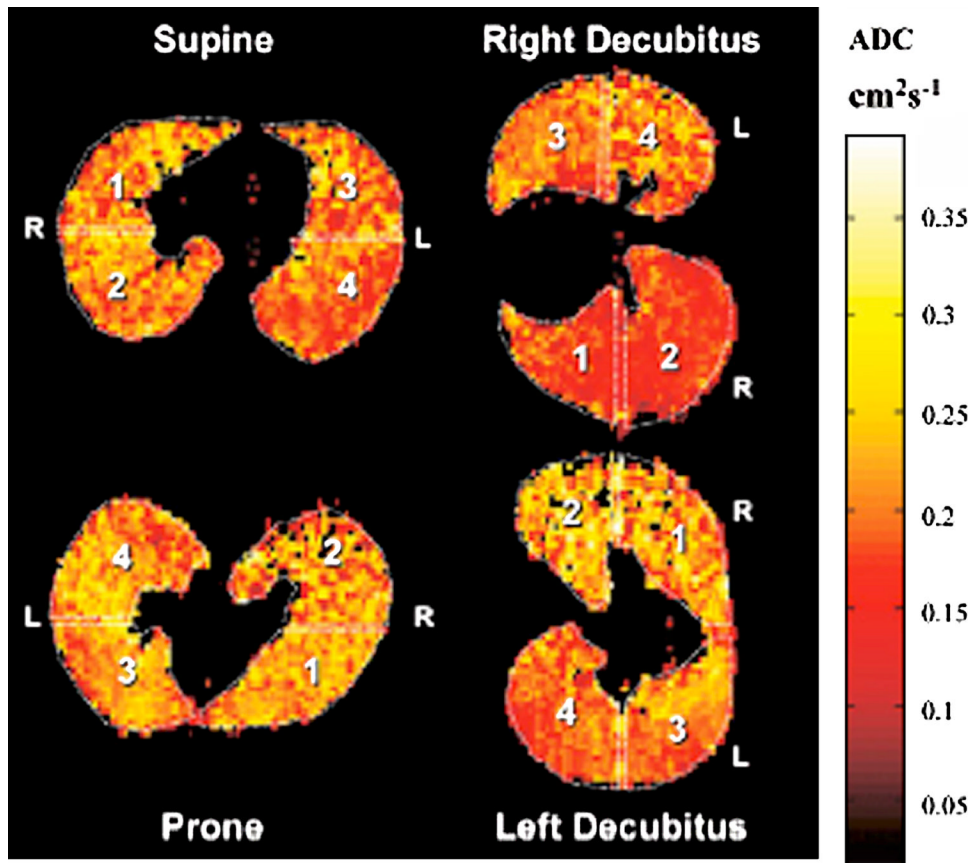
Apparent diffusion coefficient (ADC) imaging in a normal volunteer in different positions, demonstrating gravity dependent changes with decreased ADC values in dependent lung portions (reproduced from Fichele et al. J MRI 2004;20:331–335.)
